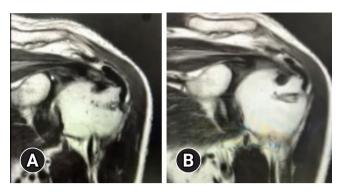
Postoperative rotator cuff integrity after onlay patch augmentation based on Sugaya [20] classification. (A) The Sugaya type 2 integrity in magnetic resonance imaging (MRI) scan. (B) The Sugaya type 3 integrity in MRI.
